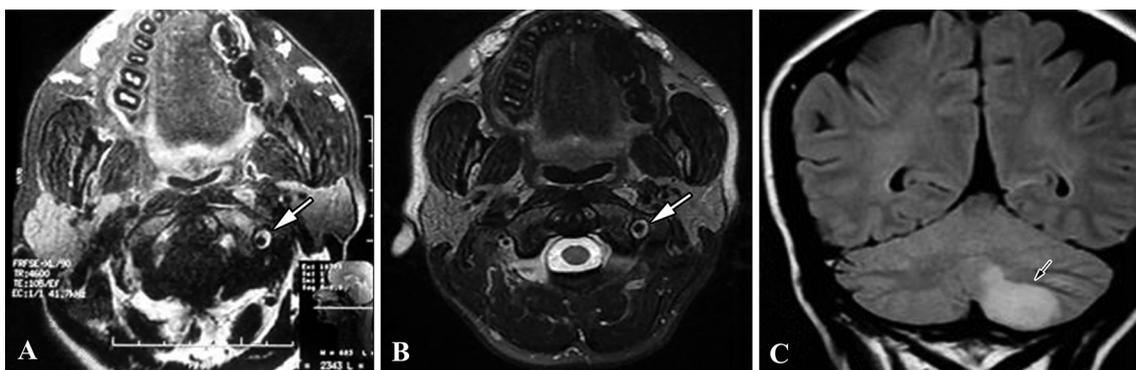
Axial MRI scans in T2-weighted fat saturation to show the left vertebral artery (arrow) with an intramural hematoma on admission (A) and three months later (B) following anticoagulant therapy. Note an infarction of the left cerebellar hemisphere (arrow) on a coronal MRI scan (C) in the PICA territory.
